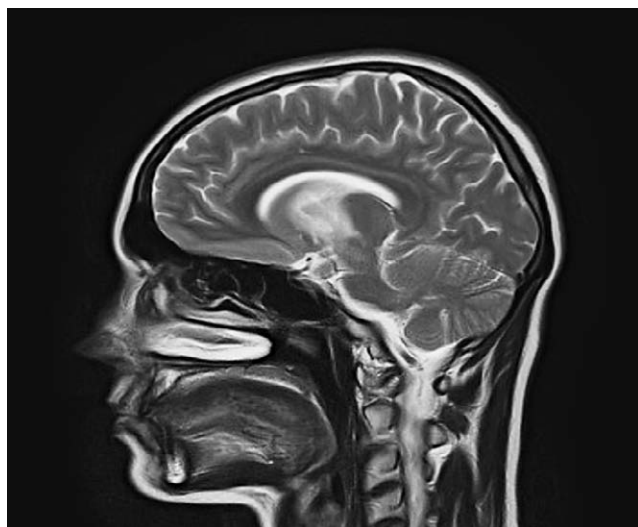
MRI of the brain of a patient with Behçet's disease and changes in the area of mesencephalon – the sagittal section
